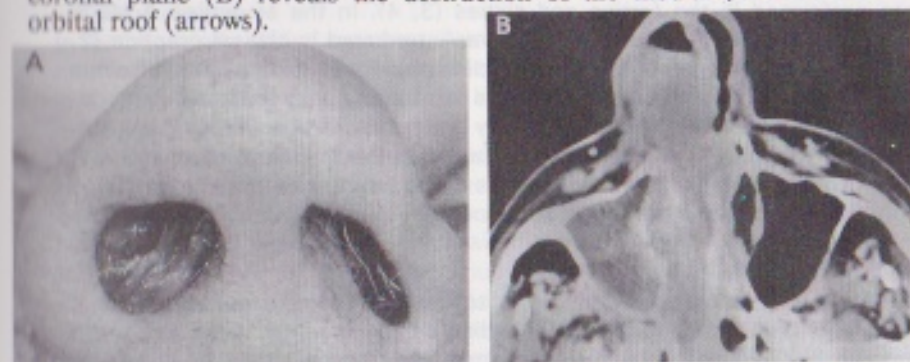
80 yrs. old patient with a melanoma of the right nasal cavity, which has eroded the lateral nasal wall, thus protruding into the right maxillary and ethmoid sinuses. The tumor has bulged the right nostril (A). Coronal CT scan (soft tissue window) reveals a complete obstruction of the right nasal cavity and paranasal sinuses (B), which is due to tumor tissue in the ethmoid and maxillary sinuses.
